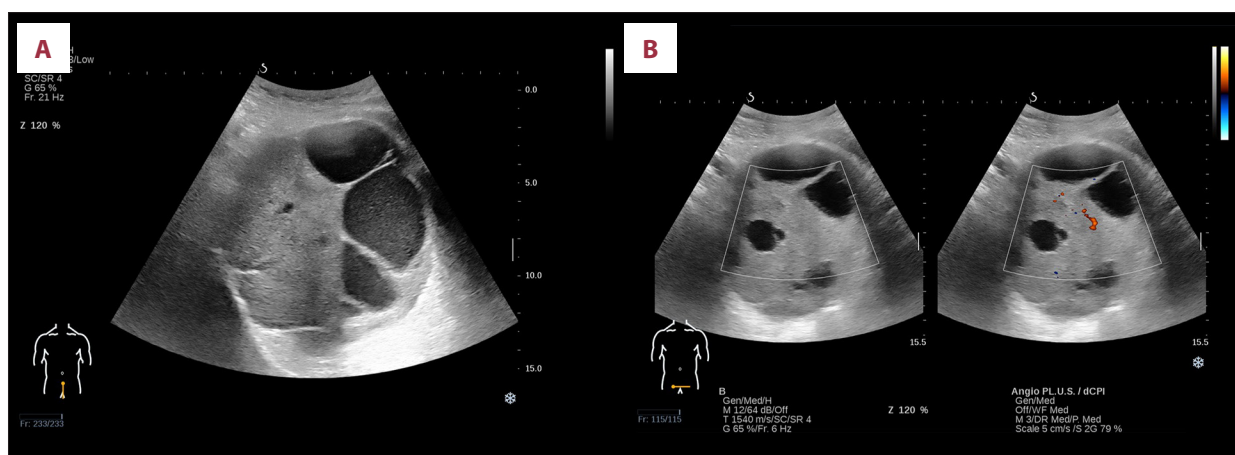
Conventional ultrasound of pelvic schwannoma. (A) Longitudinal view showing a well-circumscribed, mixed cystic-solid hypoechoic mass with multiple anechoic areas. (B) Transverse color Doppler image demonstrating minimal internal blood flow.
